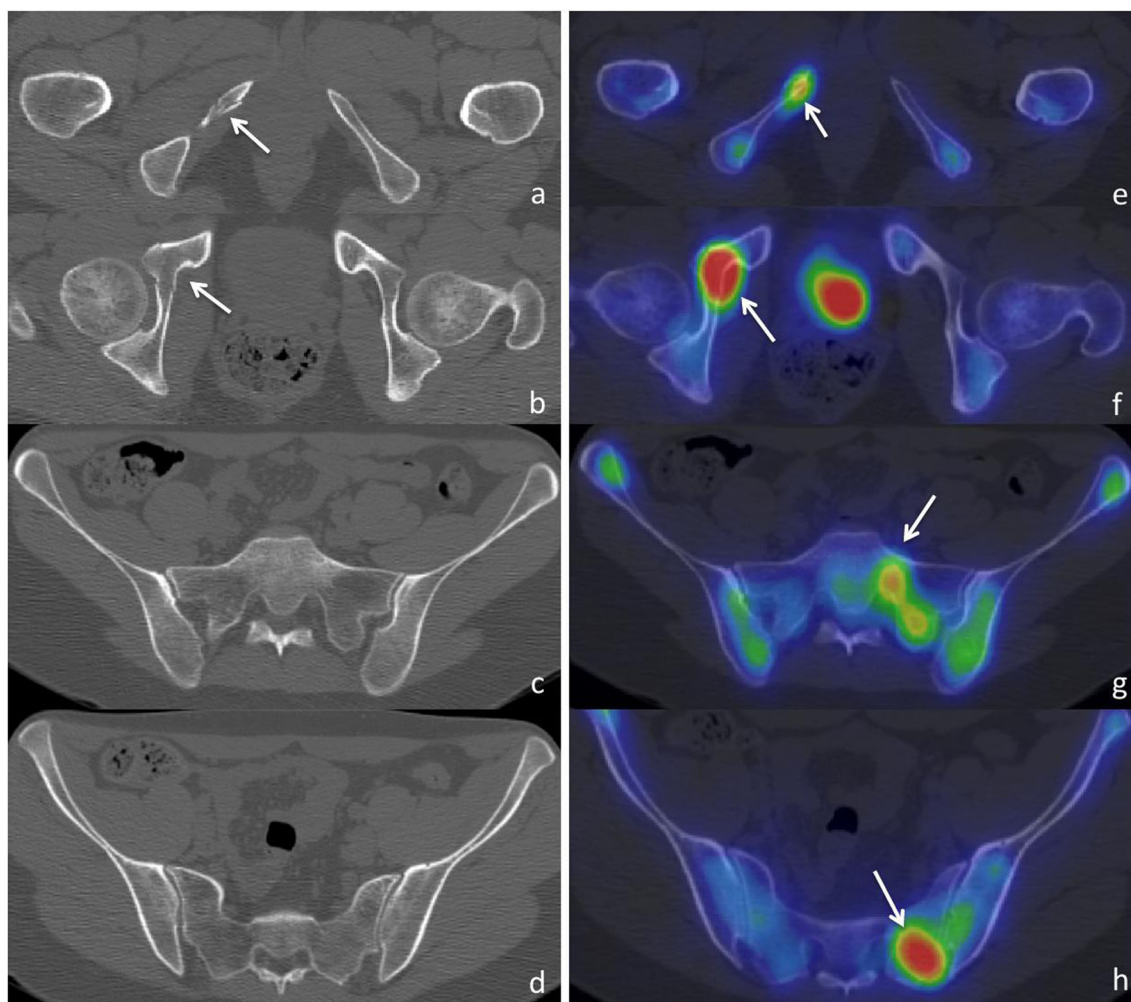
a–c A 41-year-old patient after a bicycle accident. a, e Fracture of the lower pubic ramus (*arrow*) and b, f the anterior column of the acetabulum (*arrow*). c, d On CT there are no signs of posterior
